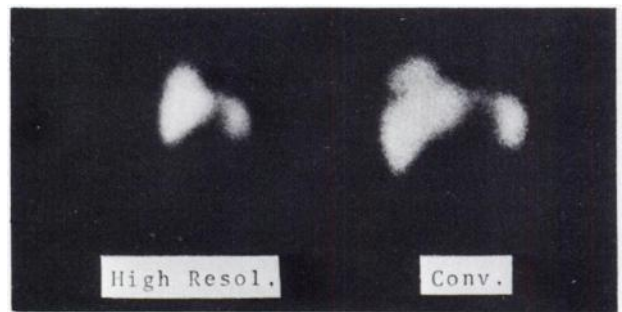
Anterior liver scintiphotos obtained with high-resolution and experimental converging collimator in 2-week-old female. Patient presented with x-ray finding of right lower thoracic mass. High-resolution image demonstrated upward projection of right lobe with some irregularity of uptake in this region. Corresponding view with experimental collimator revealing ringlike defect in upper portion of right lobe produced by eventration of diaphragm.
